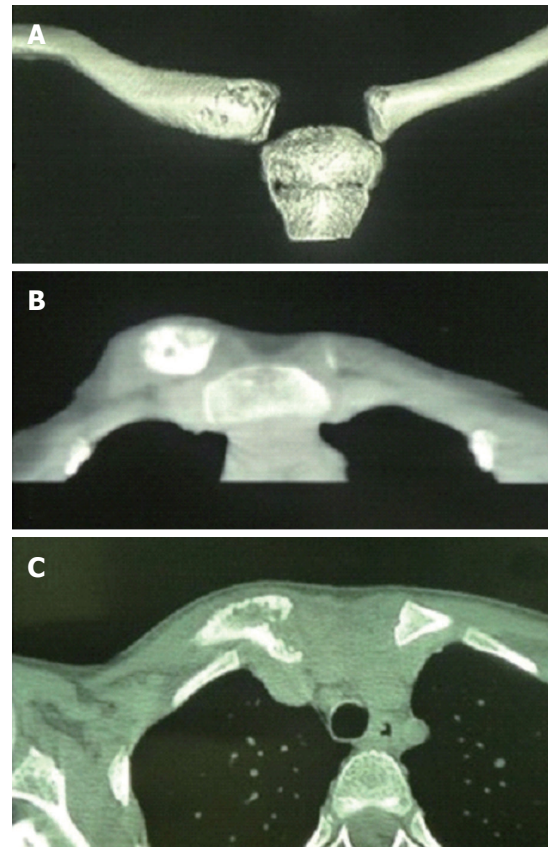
Computed tomography scan with three-dimensional reconstruction (A) of the right clavicle in a patient with condensing osteitis (B, C).
